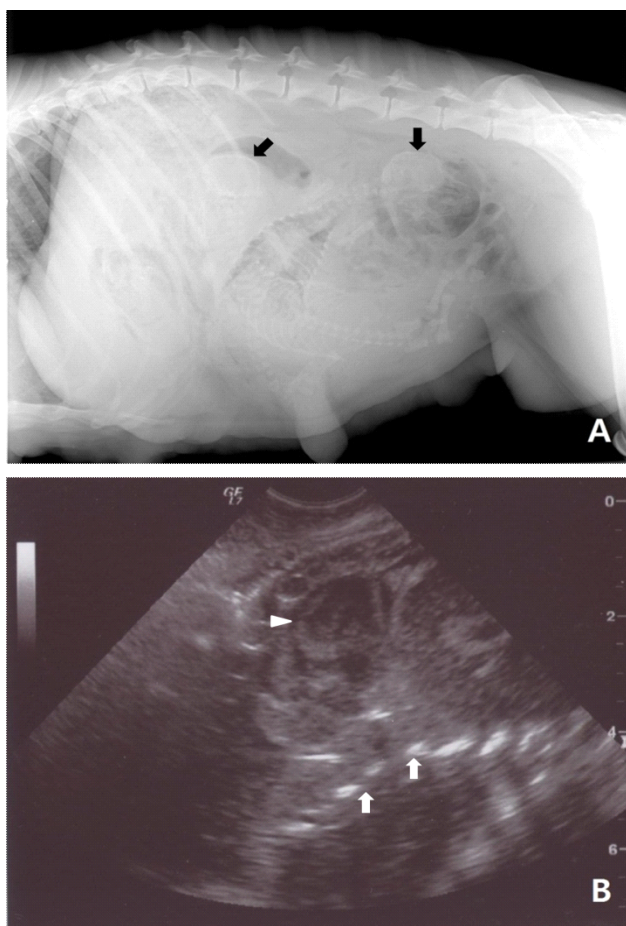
Abdominal radiography (A) and ultrasonography (B) of this case. (A) There was marked retention of two fetuses (black arrows) in the uterus. (B) There was a confirmed dead fetus without a fetal heart rate and fetal movement (white arrow head- fetal heart, white arrows-fetal ribs).
